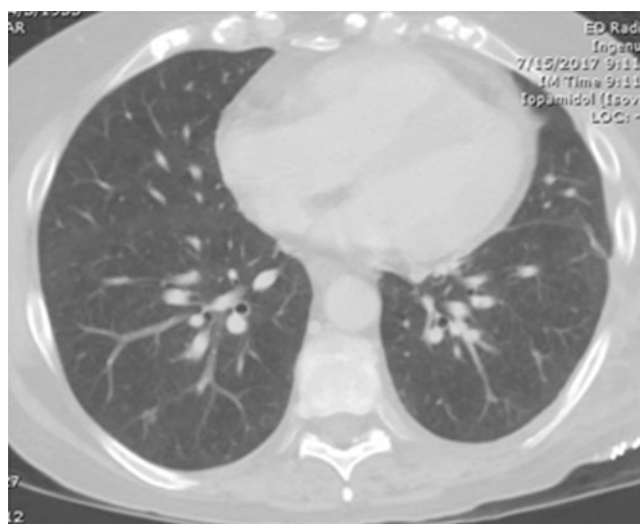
Imaging features of pulmonary veno-occlusive disease (PVOD). Chest CT image shows diffuse emphysematous changes and bilateral patchy ground-glass opacities and nodularity
